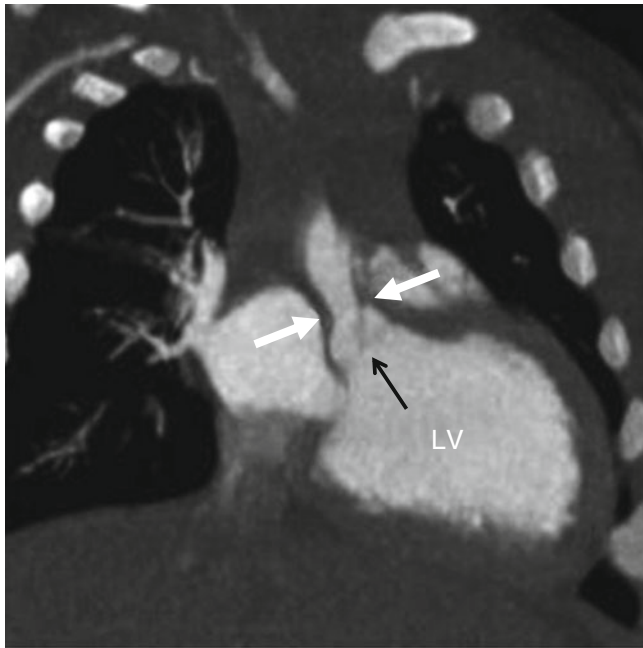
Williams syndrome with supra-aortic stenosis. Panel (a) is a coronal volumetric reconstruction demonstrating stricture (*white arrows*) of the ascending aorta. *Black arrow* aortic valve *LV* left ventricle (Reproduced from Dillman and Hernandez [36]. With kind permission of American Roentgen Ray Society, Leesburg, VA)
